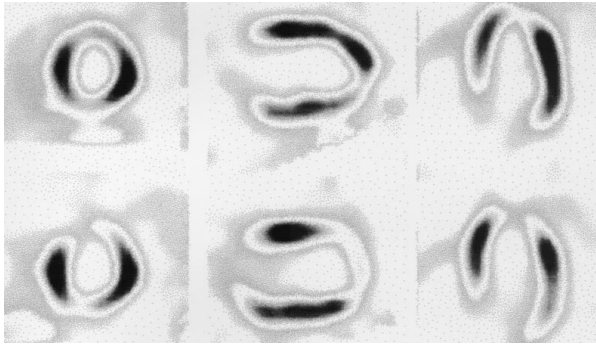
Baseline resting and LDD SPECT of a patient with 1-vessel coronary artery disease. Same image disposition as in Figure 2. The baseline anterior defect appears clearly reduced in the LDD images. After coronary angioplasty of the left anterior descending artery, significant functional recovery was observed.
